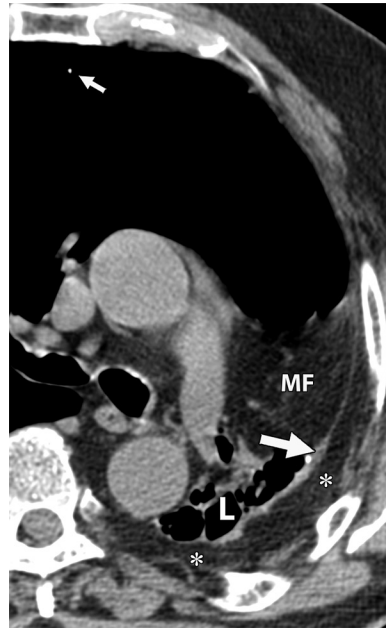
Extensive lung destruction and residual tuberculosis-induced changes. Axial CT image through the left hemithorax shows thickening and calcification of the pleura (large arrow), marked proliferation of the extrapleural fat (*), and cicatricial atelectasis with traction bronchiectasis in the left lung (L). The contralateral lung is hyperinflated, with an isolated calcified granuloma (small arrow). A prominent mediastinal shift is ipsilateral to the cicatricial changes. MF = mediastinal fat.
